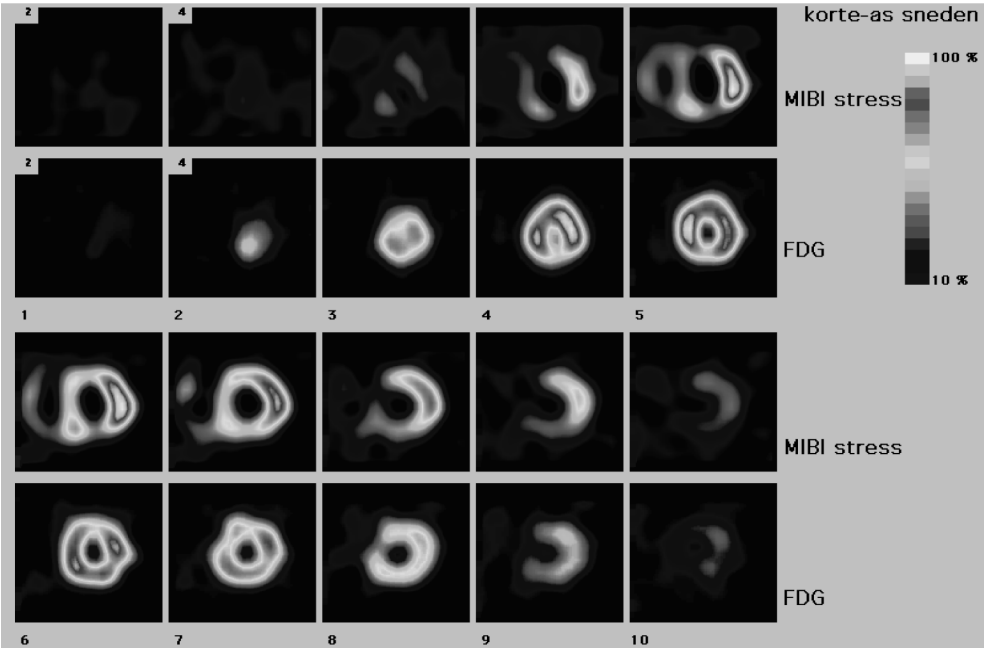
Short-axis view of a dual isotope simultaneous acquisition (DISA) SPECT image. The first row demonstrates row is shows a large perfusion defect in the apex, mid-anterior, septal and inferior wall after (dipyridamole) stress ^{99m}Tc-sestamibi. The simultaneous performed FDG study on the second row shows adequate uptake in these regions, indicating ischemia or preserved viability.
